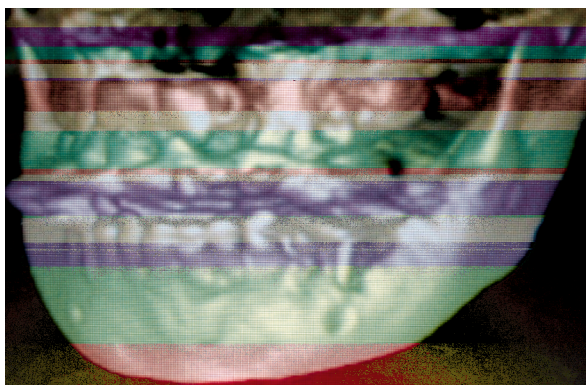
Showing cone beam ct scan on maxilla and mandible of 7 years old male patient with closure of anterior palatal fistula by distraction osteogenesis.
